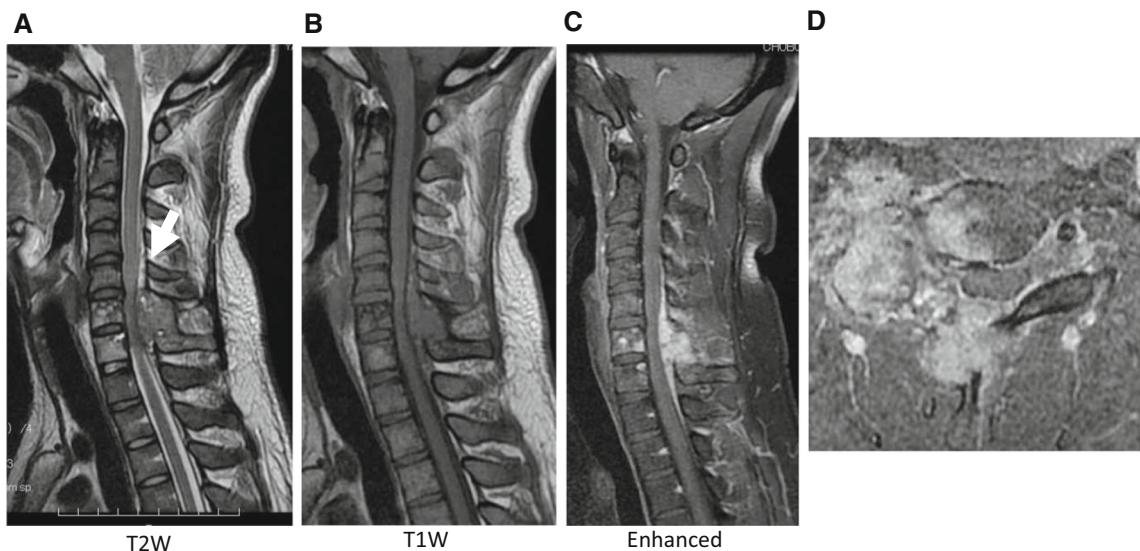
a, b Sagittal cervical magnetic resonance imaging (MRI) showed an expansile, well-demarcated, inhomogeneous (iso in T1-weighted images and hypo- and hyperintense in T2-weighted images) mass that extended into the canal (arrow) at the C4-T1 levels.
